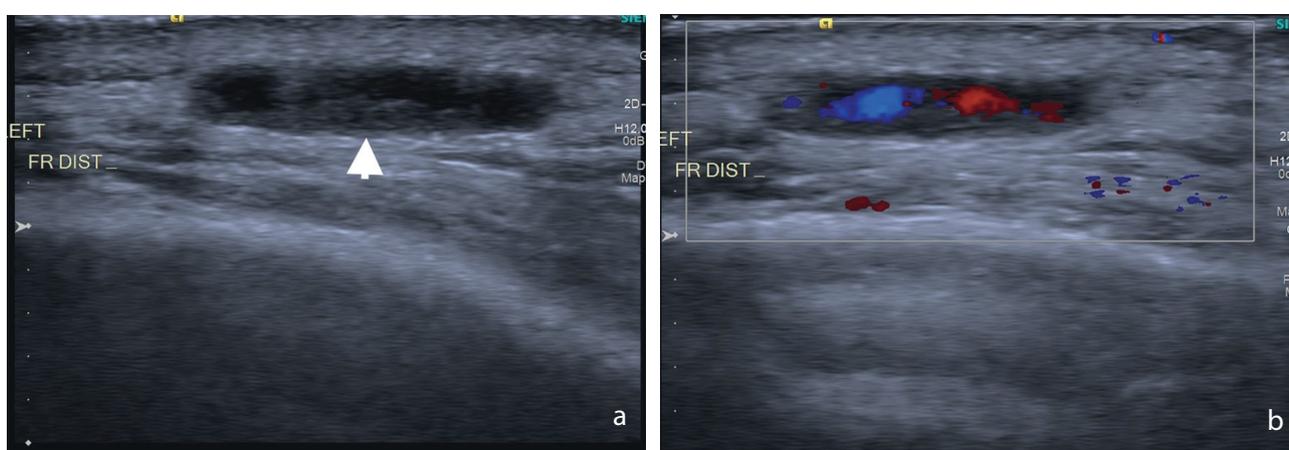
(a) Gray-scale US demonstrates a hypoechoic atheroma plaque (arrow) with an eccentric luminal narrowing in the temporal artery. (b) Color flow Doppler US reveals a filling defect in the temporal artery due to atheroma plaque.
